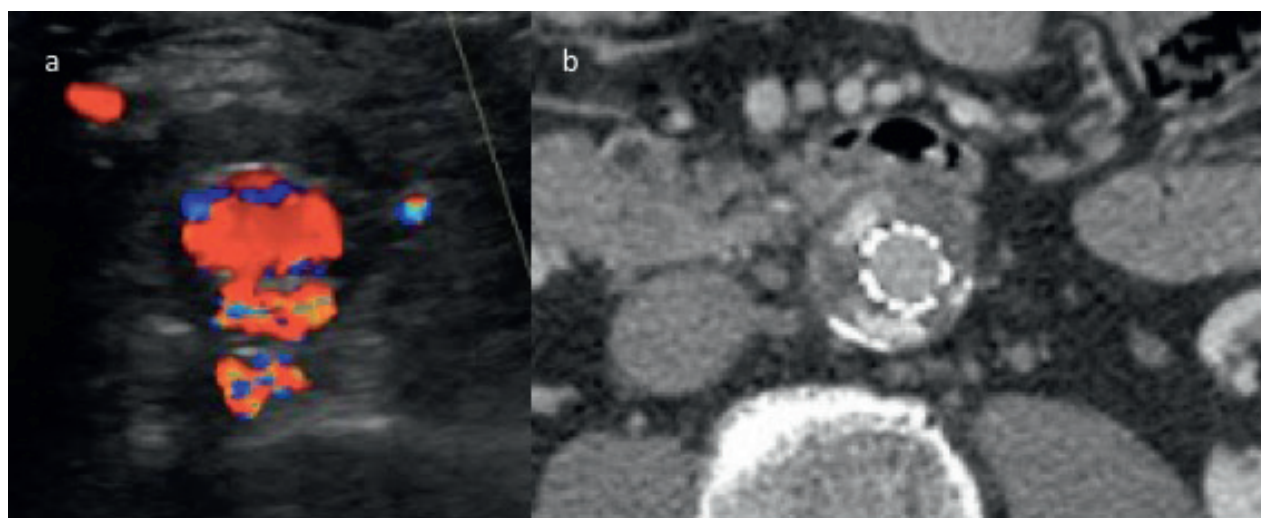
Type II Lumbar Endoleak. (a) Axial Doppler image demonstrates Doppler flow posteriorly within the sac from lumbar vessels. (b) Axial contrast enhanced CT confirms endoleak posteriorly within the sac from lumbar vessels.
